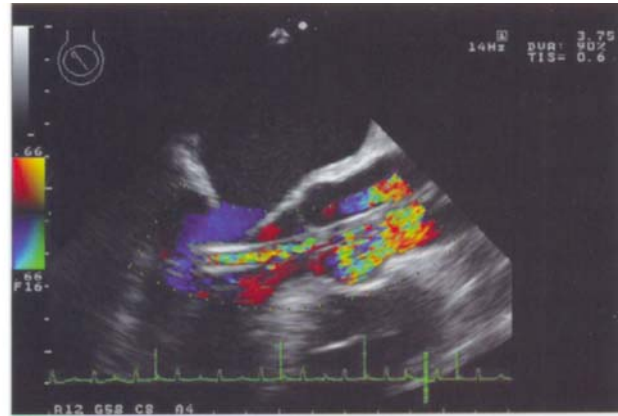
Mid-oesophageal long-axis view showing a left ventricular Impella® axial flow pump in the correct position with colour flow Doppler. Note the laminar flow toward the openings at the pump tip, and the turbulent flow in the rotator chamber and at the outflow positioned in the ascending aorta. The arrow indicates the outflow openings of the pump.
